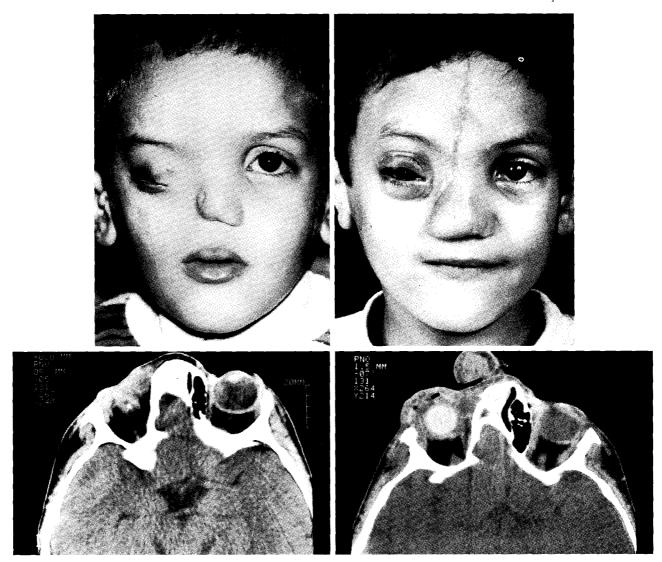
Example of expansion achieved using orbital implants alone in a patient referred late. (*Above, left*) A 4-year-old male child with right microphthalmos in the context of a hemifacial malformation that included a right frontal encephalocele and right heminasal agenesis with proboscis and atresia of the nasal airway. (*Above, right*) Patient at 7 years, after evisceration and placement of a silicone implant, bone grafting of the superior orbital rim, conjunctival sac reconstruction, medial and lateral canthopexies, ptosis correction, first stage heminasal reconstruction with a forehead flap, and fitting of an ocular prosthesis. (*Below, left*) Axial computed tomography scan taken when the patient was 4 years old showed a cystic, rudimentary right eye within a hypoplastic orbit. (*Below, right*) Axial computed tomography scan taken when the patient was 5 years old, showing the expansion in right orbital volume achieved after evisceration and placement of a silicone implant.
